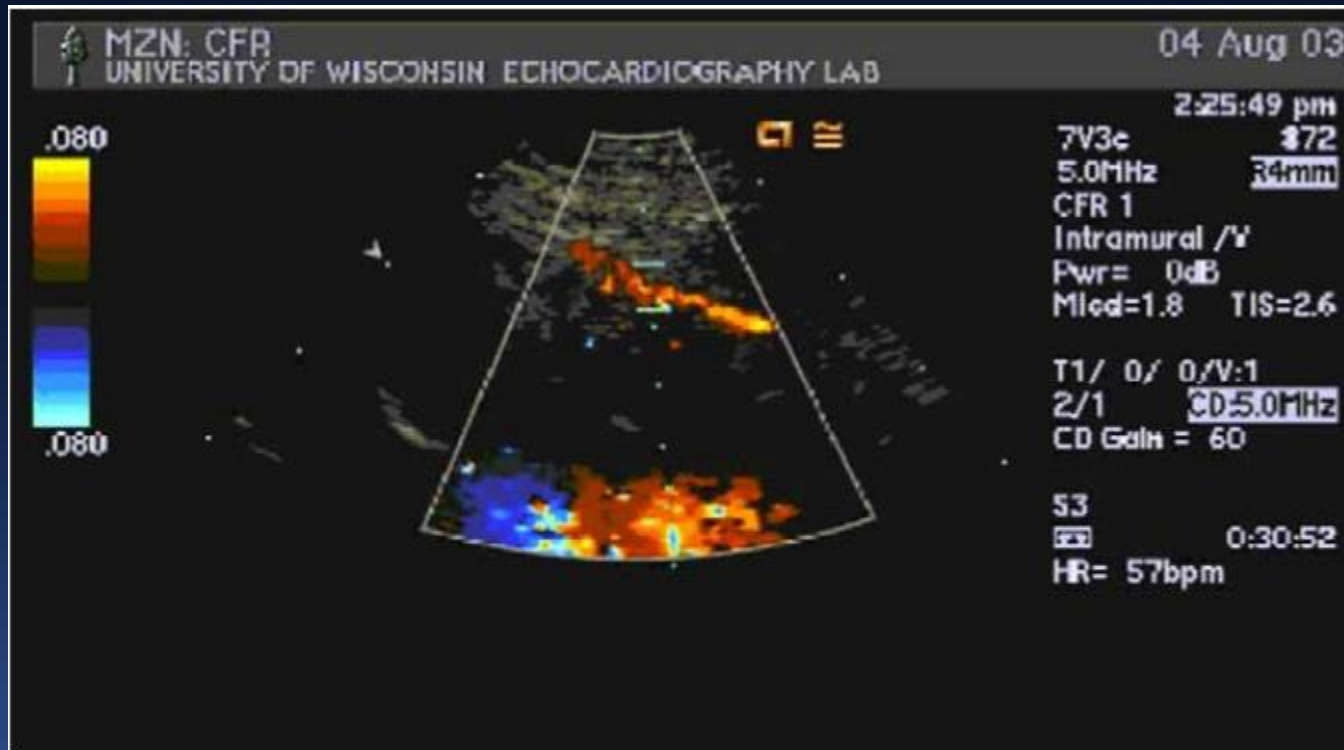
Blood flow in the left anterior descending coronary artery obtained using a modified, low parasternal long axis view.
